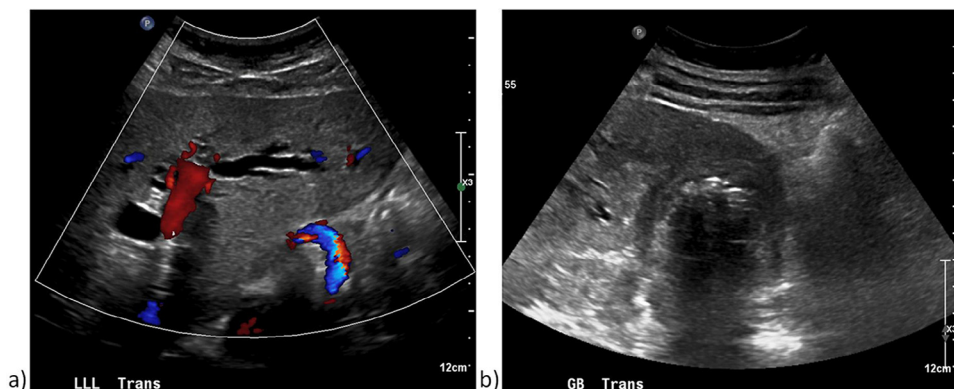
Ultrasound images: (A) Markedly dilated intrahepatic biliary ducts within the left hepatic lobe. (B) Marked gallbladder wall thickening, cholelithiasis, and adjacent hypoechoic hepatic lesions or invasion.
